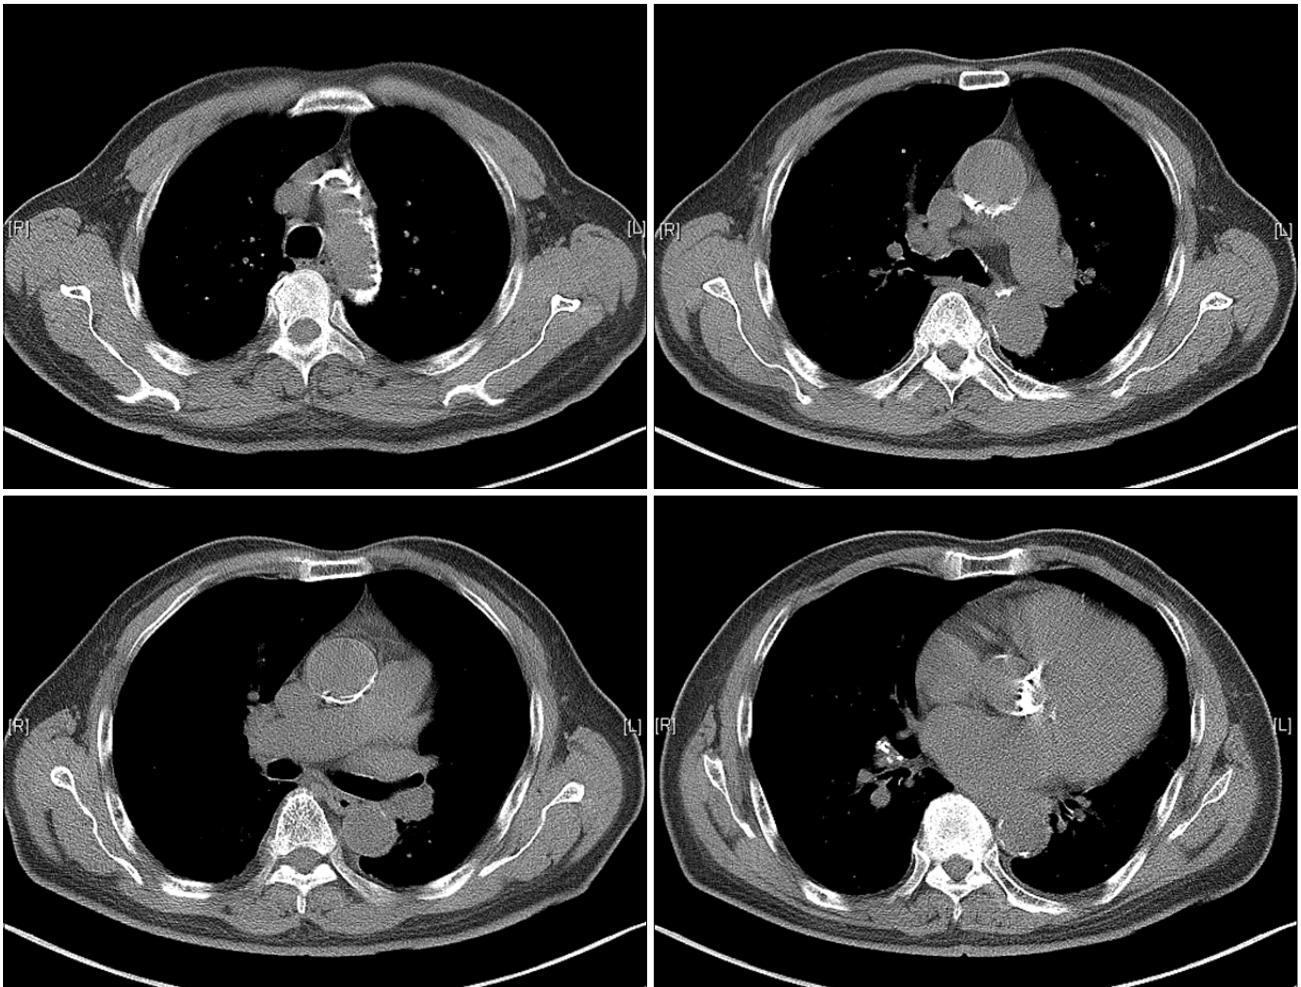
Preoperative computed tomography showed severe calcification of the aorta.
